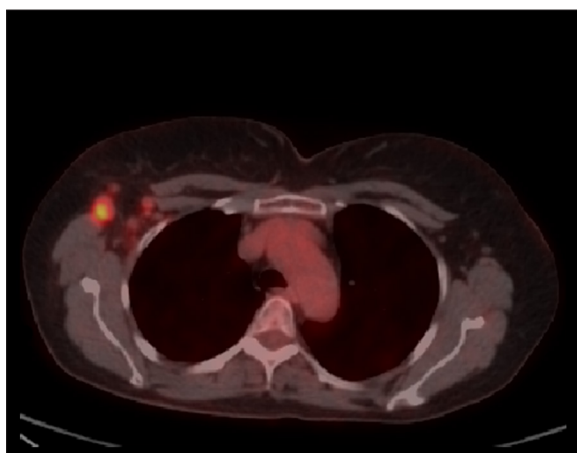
In the same patient, enlarged metastatic ipsilateral axillary lymph nodes with a SUV_{max} value of 8.4 were detected.
